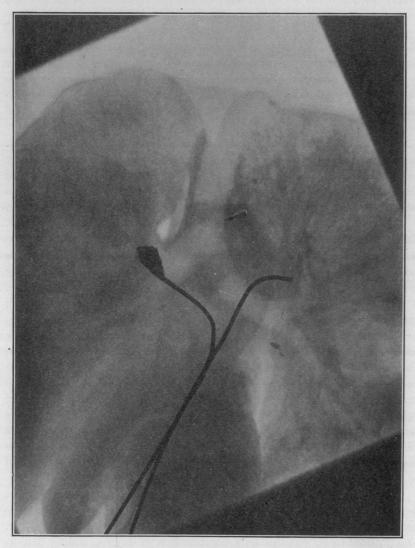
Roentgenogram of lungs with probes passing from the heart up into the pulmonary artery showing missile lodged in the first bifurcation of the right pulmonary artery.
